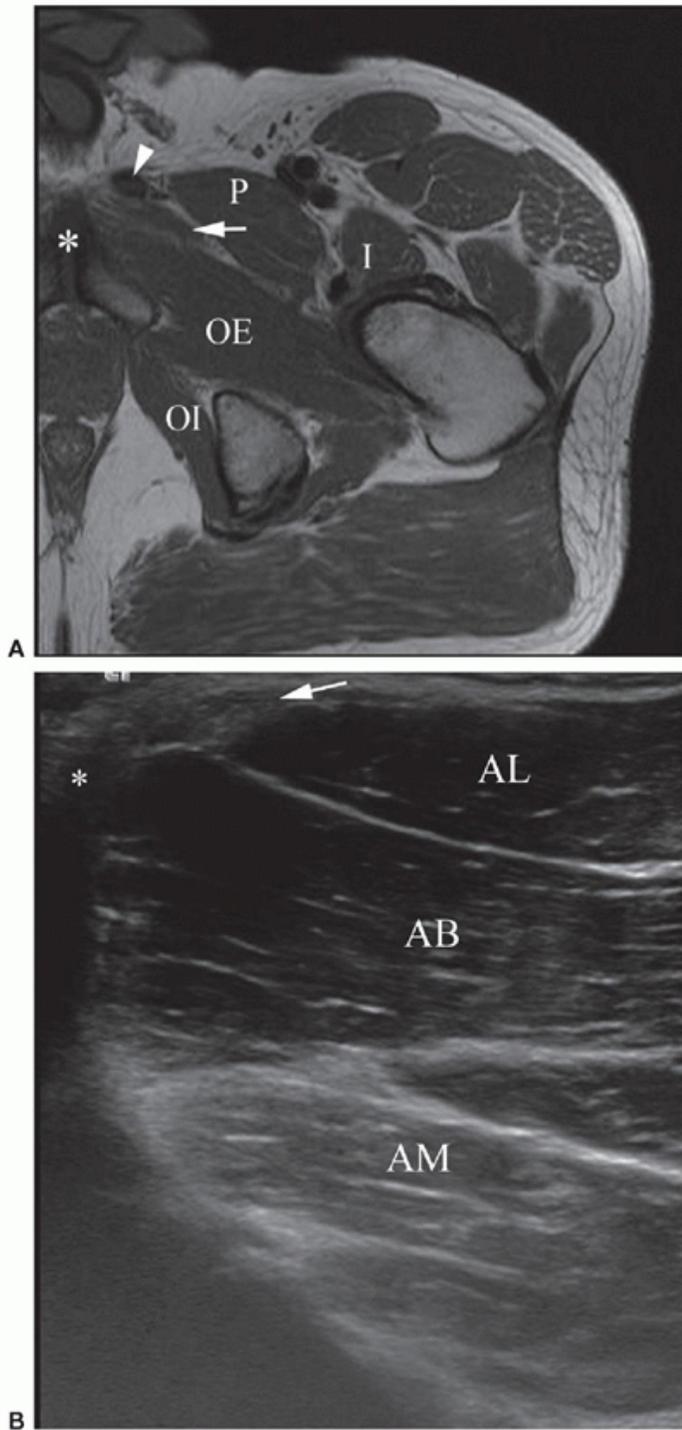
Normal views of the adductor origins. A: Axial T1W MRI shows the adductor origin, including adductor longus (arrowhead), brevis (arrow), and obturator externus (OE) with adjacent Iliopsoas (I), obturator internus (OI), pectineus (P), and pubic symphysis (asterisk). B: Short-axis sonogram of the thigh inferior to (A) shows the adductor longus tendon (arrow) and muscle (AL) with adductors brevis (AB) and magnus (AM) lying deep and pubic symphysis (asterisk) lying superficial.
